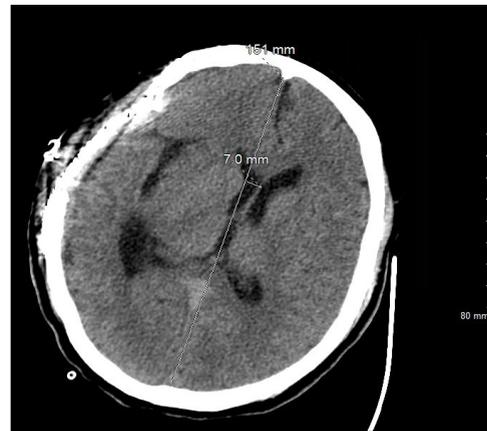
CT demonstrating interval mesh cranioplasty with a decrease in leftward midline shift
